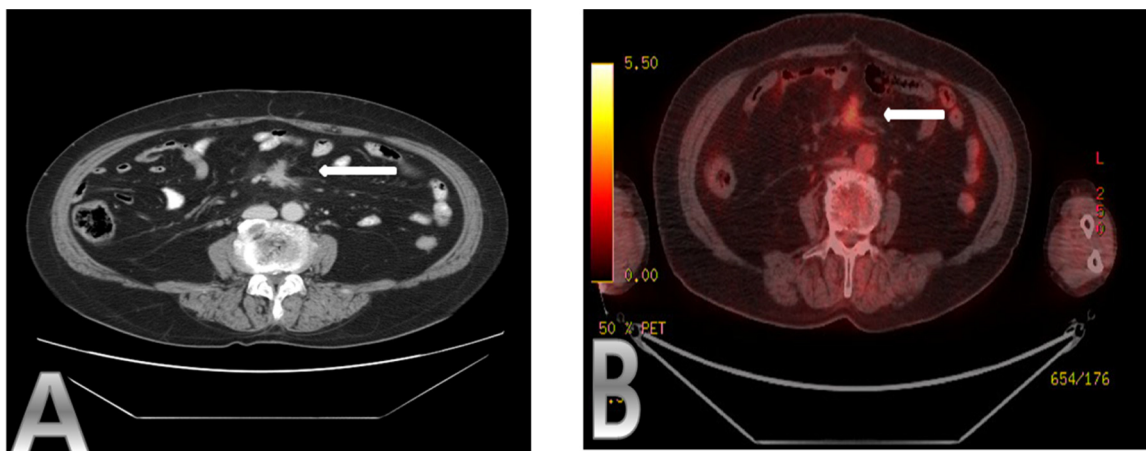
Abdominal CT shows an ill-defined mass with perilesional infiltration in the mesentery. (A) PET CT shows hypermetabolism in the soft tissue infiltration of the mesentery.(B).
